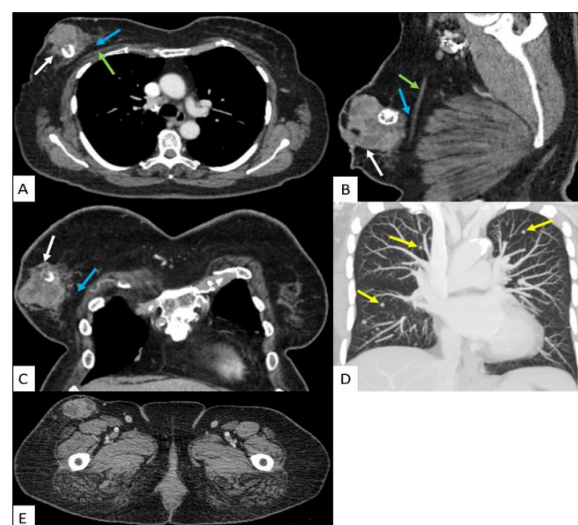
Contrast-Enhanced CT Images.
